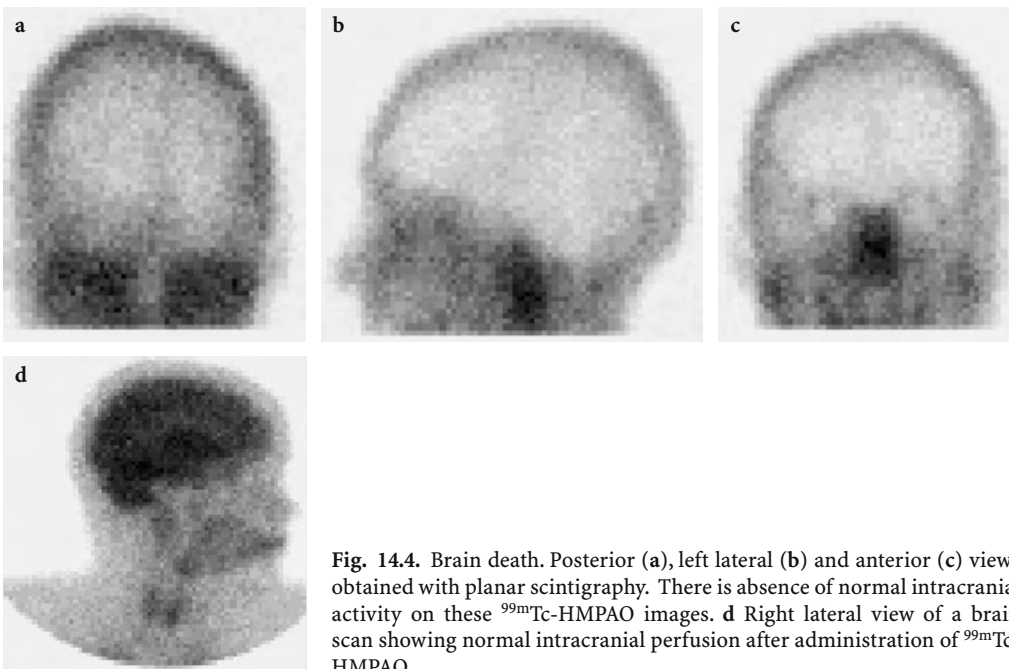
Brain death. Posterior (a), left lateral (b) and anterior (c) views obtained with planar scintigraphy. There is absence of normal intracranial activity on these ^{99m}Tc -HMPAO images. d Right lateral view of a brain scan showing normal intracranial perfusion after administration of ^{99m}Tc -HMPAO
